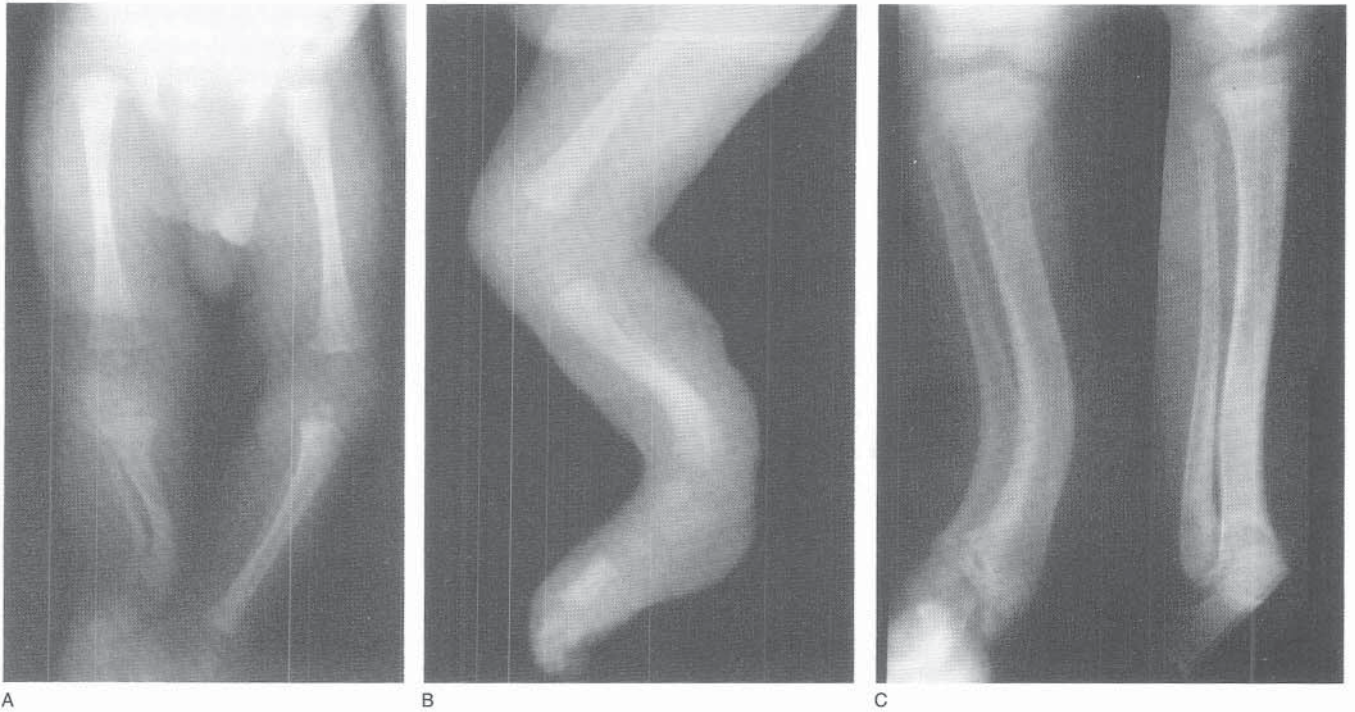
A, Radiograph of a newborn with a severe posteromedial bow. B, Lateral radiograph. C, Appearance at age 7. The medial bow has not corrected and there is a 6-cm length discrepancy. Angular correction and lengthening are indicated.
